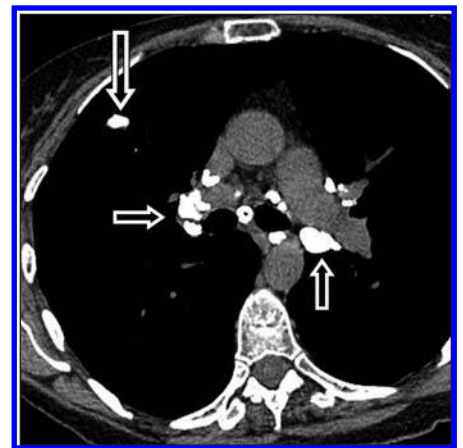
Postinfectious inactive tuberculosis. Transverse CT image of chest shows multiple calcified mediastinal and hilar lymph nodes (short arrows) as well as calcified parenchymal opacity (long arrow).
